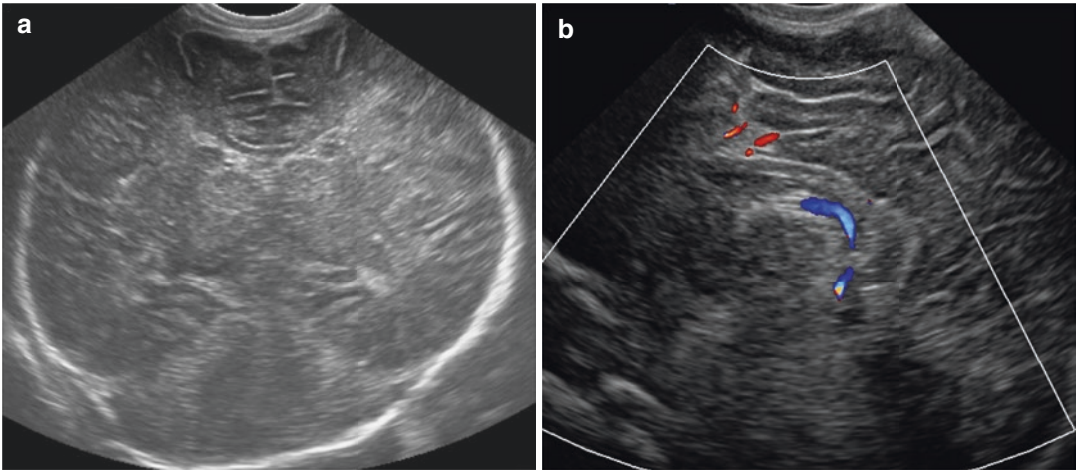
A 39-week gestation female presents on day of birth with meconium aspiration and sonographic signs of acute hypoxic-ischemic injury (a, coronal and b, sagittal). The ventricular system and extra-axial spaces are completely effaced. There is bilateral diffusely increased
